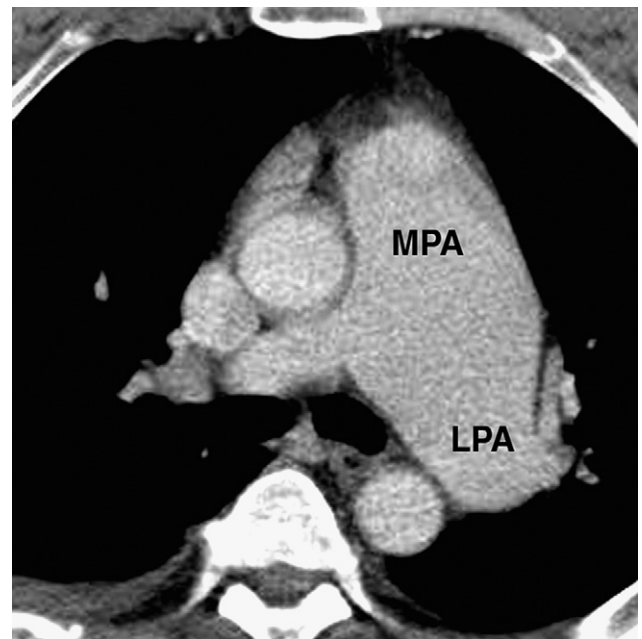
Axial multidetector computed tomography of the chest shows poststenotic dilatation of the main pulmonary artery (MPA) and left pulmonary artery (LPA), with sparing of the right pulmonary artery. Used with permission.³⁶
